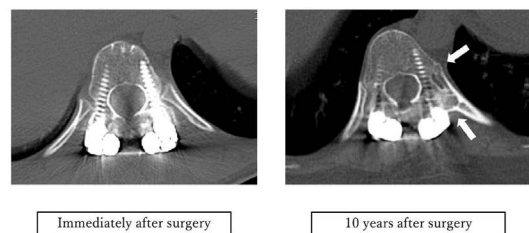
A CT image at 10 years after surgery demonstrated autofusion at the costocorporeal and the costotransverse joints.
